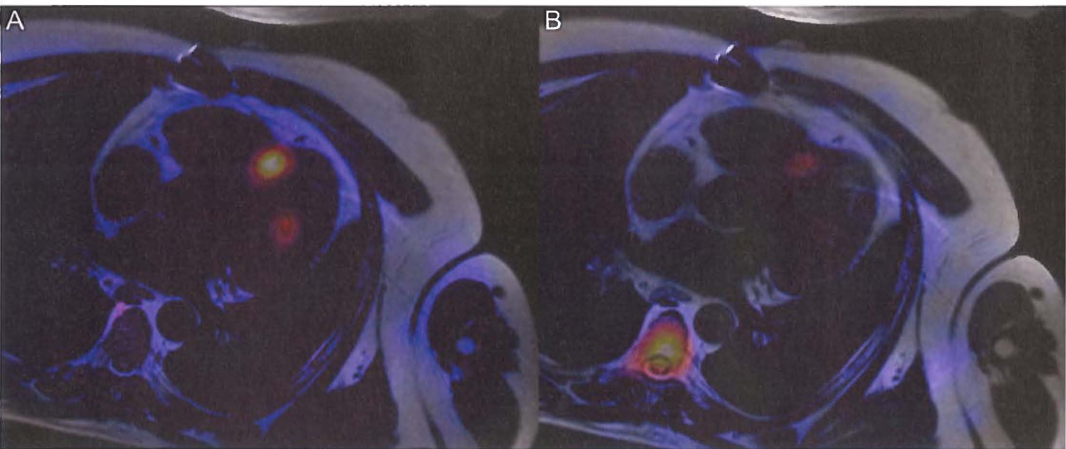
A, fusion of ¹⁸F-DOPA PET and MRI confirms the presence of two lesions in the left ventricular myocardium. B, fusion of MRI and SRS shows only one myocardial lesion.
